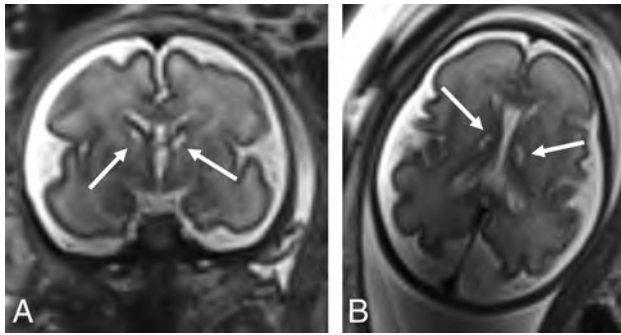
Coronal (A) and axial (B) T2-weighted images of a 30-week surviving twin following spontaneous sIUFD at a GA of 18 weeks, showing caudothalamic cystic changes (arrows).
